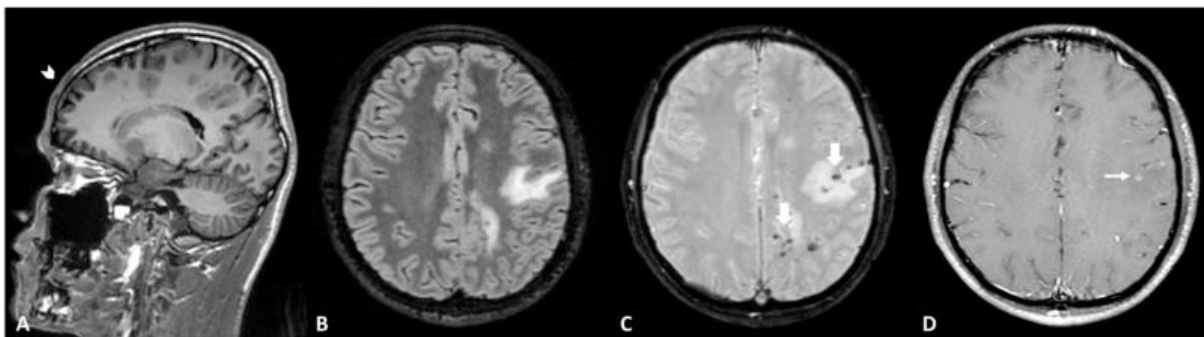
MR images of a 29 year-old man with linear scleroderma *en coup de sabre* associated with Parry Romberg Syndrome. Sagittal T1-weighted MR image (A) demonstrates right hemifacial atrophy primarily involving the skin and subcutaneous fat (arrow head). Axial FLAIR (B) and susceptibility-weighted (C) images demonstrate abnormal hyperintensity of the left frontal and parietal subcortical white matter with innumerable punctate foci of susceptibility (thick arrow), respectively. Axial enhanced T1-weighted MR image (D) demonstrates left frontal subcortical white matter lesion with enhancement (thin arrow).
